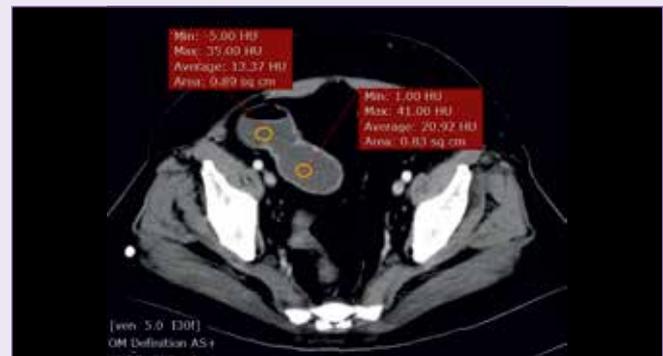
Axial section of follow-up enhanced CT which shows that the density of the gallstone (straight blue arrow) and the adjacent fluid (curved blue arrow) within the bowel lumen is almost similar thus making it difficult to identify
